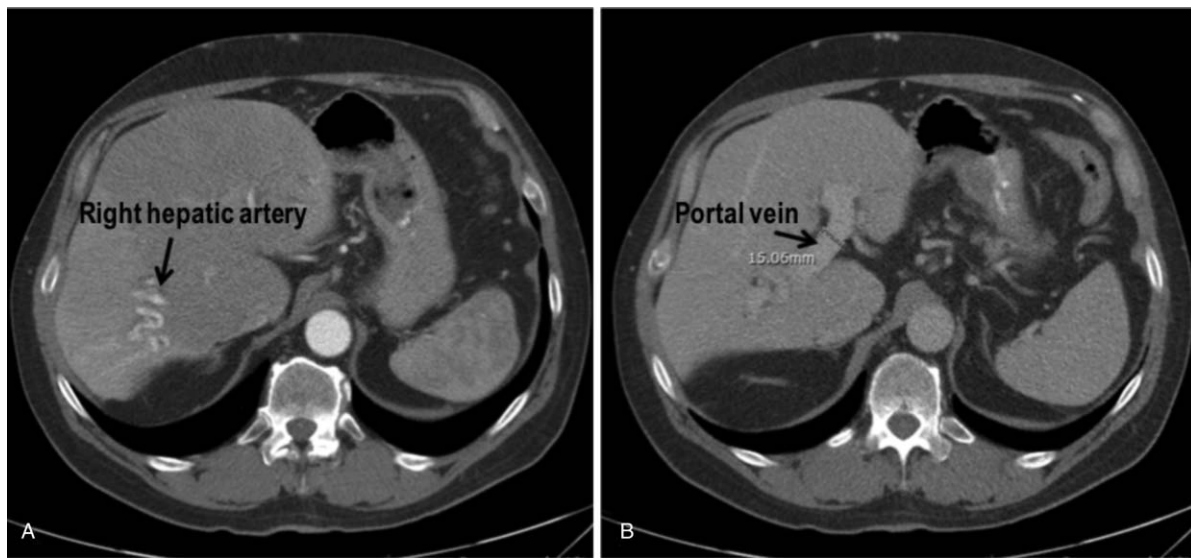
Magnetic resonance imaging of the abdomen demonstrating hepatic artery to portal vein shunting. (A) Irregular liver density and enlarged branches of right hepatic artery. (B) Enlarged portal vein and atrophy of right lobe of liver.
